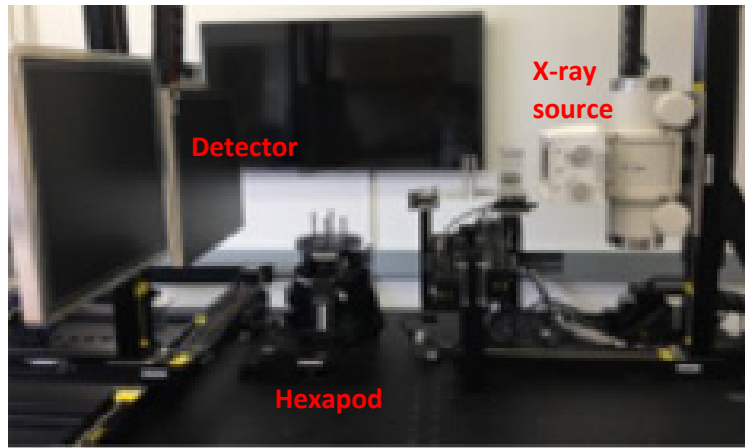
The CBCT test bench system
